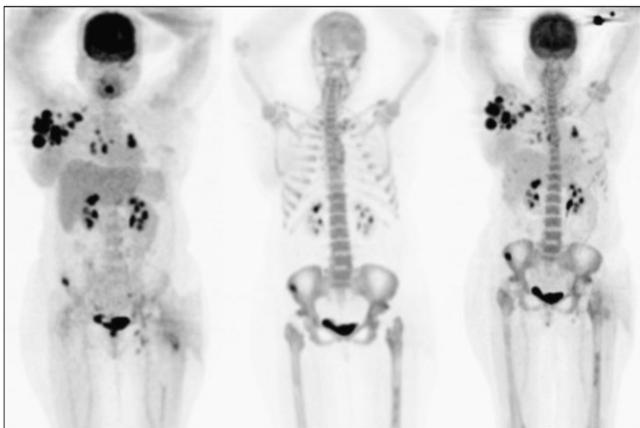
Comparative PET scans in patient with Ewing sarcoma acquired with: (left) ^{18}F -FDG, (middle) ^{18}F , and (right) combined $^{18}\text{F}/^{18}\text{F}$ -FDG “cocktail.”
